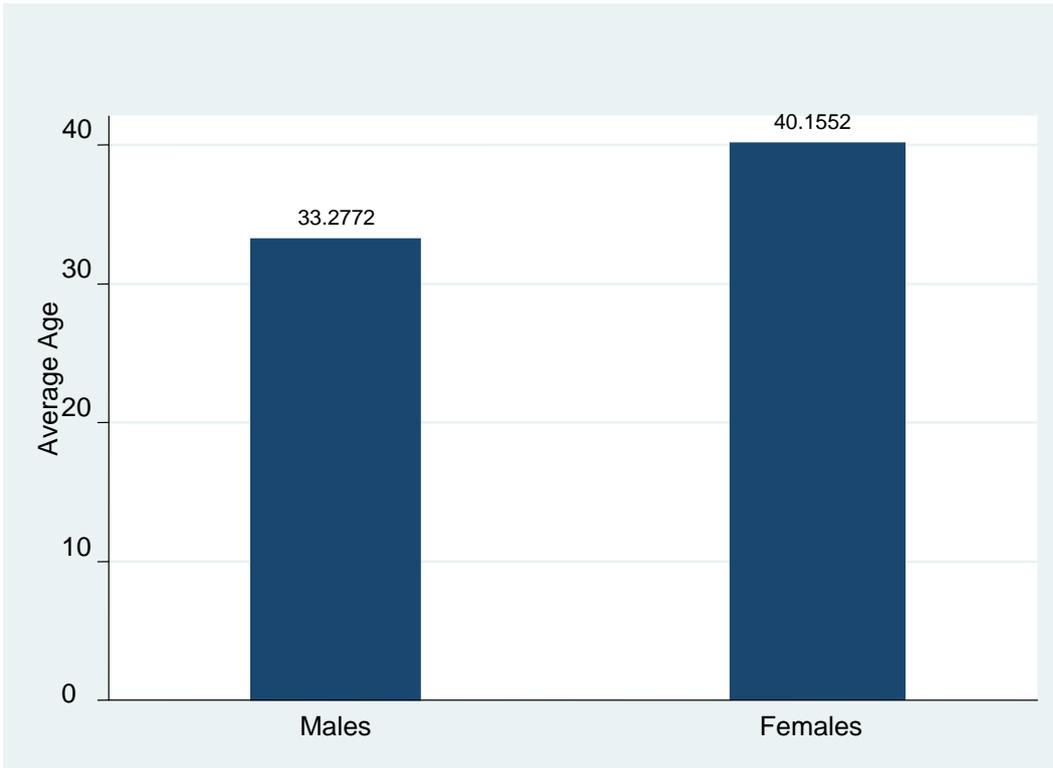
Gender Distribution of patients with blunt trauma where CT brain and C-spine were performed.
